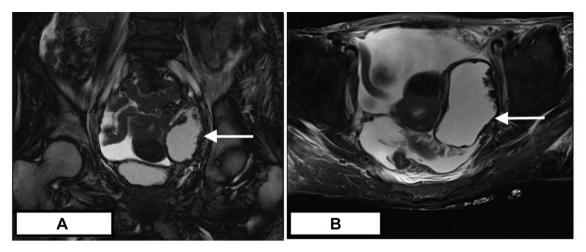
(A) Coronal section view and transverse section view (B) of abdominal MRI scan reveals an elongated, tubular, T2 bright lesion in the left adnexa with a thick wall, an incomplete septum and diffuse irregular mural excrescences, measuring 6.2×7.4×4.2 cm (arrow).
